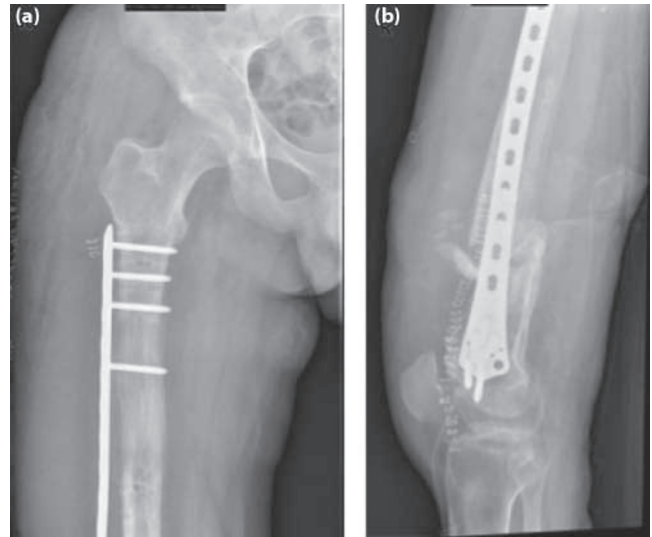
a) AP and b) lateral radiographs showing docking site grafting, Judet's procedure and plate stabilisation.
